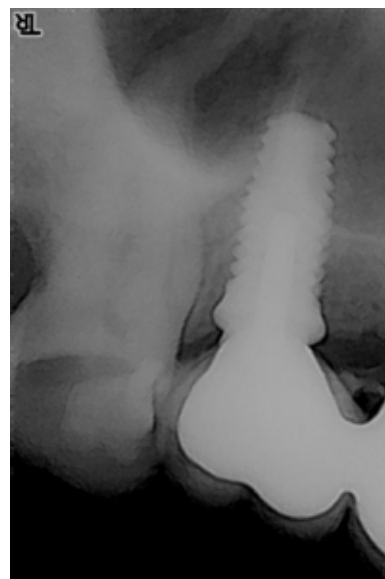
Periapical radiograph of platform switching technique.
